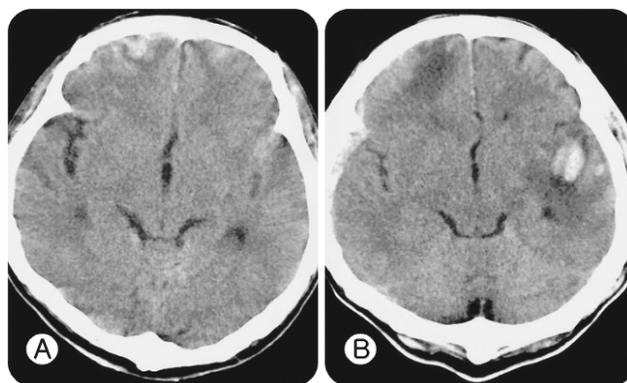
Computed tomographic scans of a 64-year-old patient who was involved in a road traffic accident and had an admission Glasgow Coma Scale score of 9. (A) initial computed tomographic scan showing diffuse bilateral traumatic subarachnoid hemorrhage localized on the left sylvian fissure and contusion of the right frontal lobe. (B) follow-up computed tomographic scan obtained 24 hours later showing progressive left temporal parenchymal damage and right fronto-temporal subdural hemorrhage.
